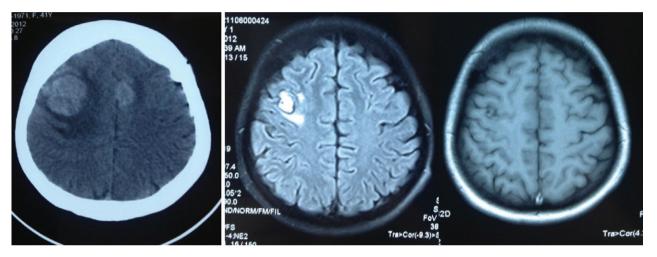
Brain computed tomography and magnetic resonance imaging scan during six cycles of first-line therapy.
